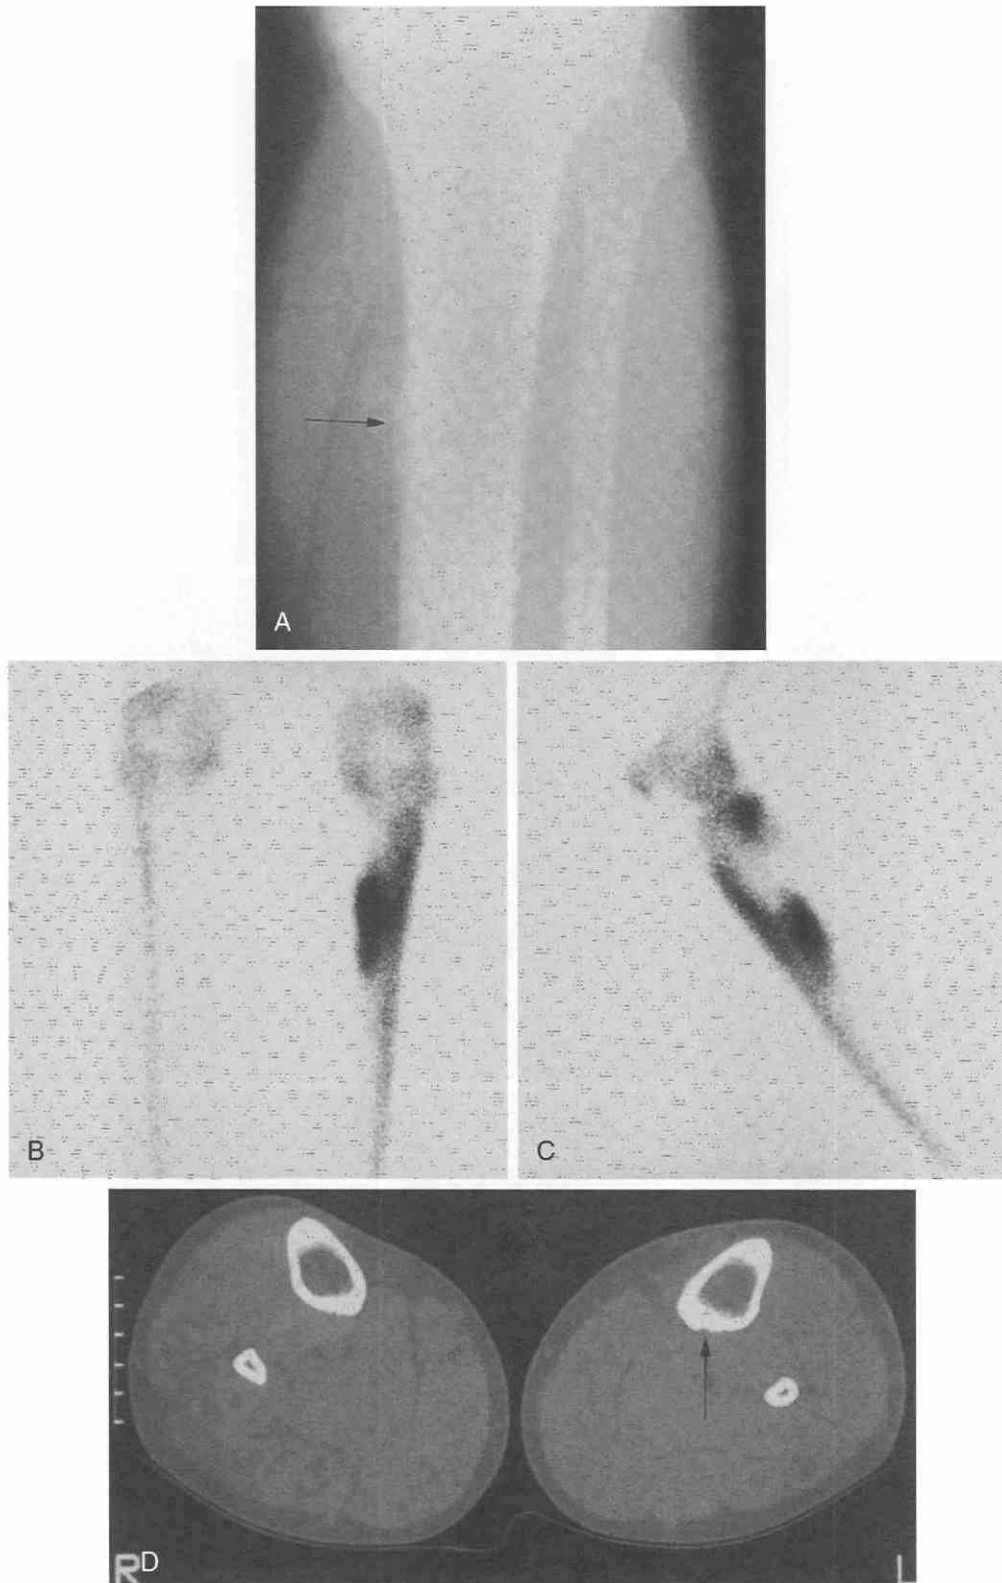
CT scan of stress fracture. *A*, An anteroposterior radiograph of the proximal left leg shows faint periosteal reaction at the medial proximal tibia (*arrow*). *B* and *C*, Frontal and lateral bone scan shows uptake at the posteromedial proximal tibia. *D*, CT scan shows a linear cleft at the posteromedial cortex of the left tibia (*arrow*), indicative of a fatigue fracture in this marathon runner.
